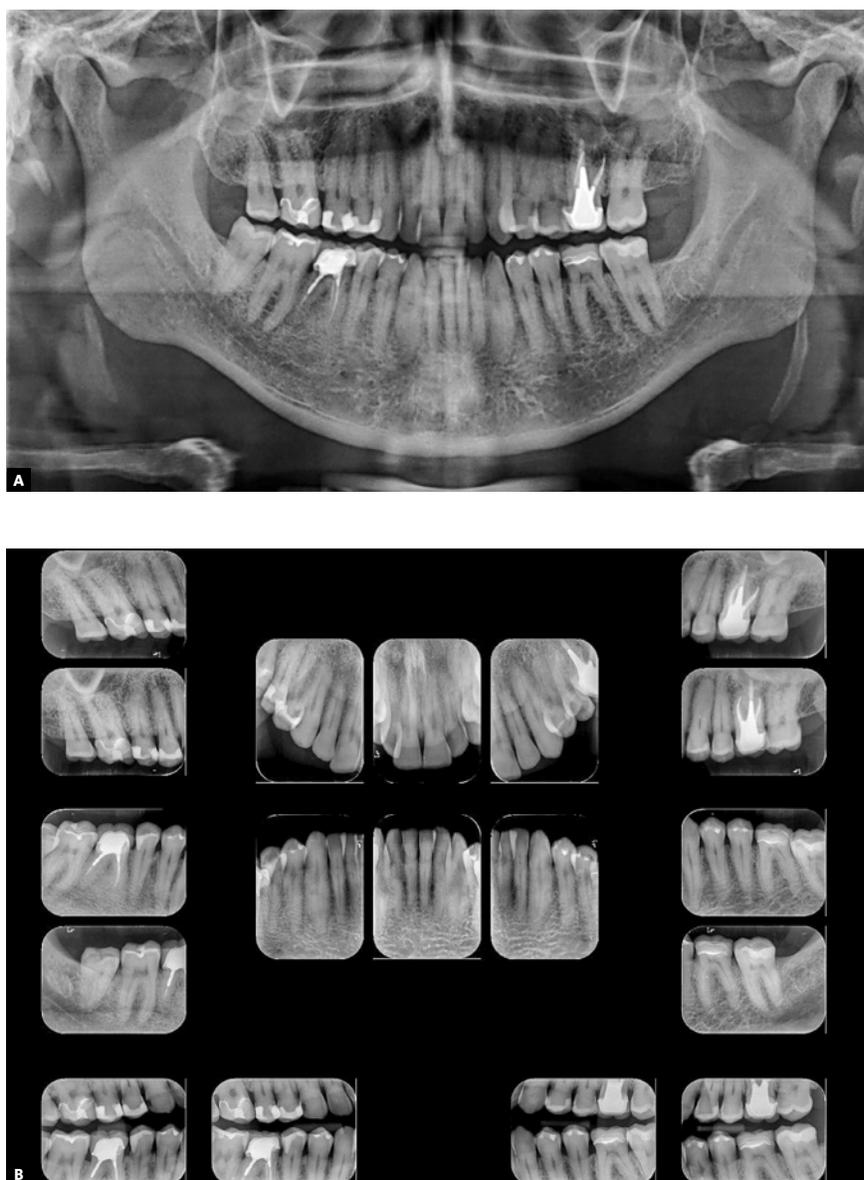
Initial panoramic (A) and periapical (B) radiographs.
